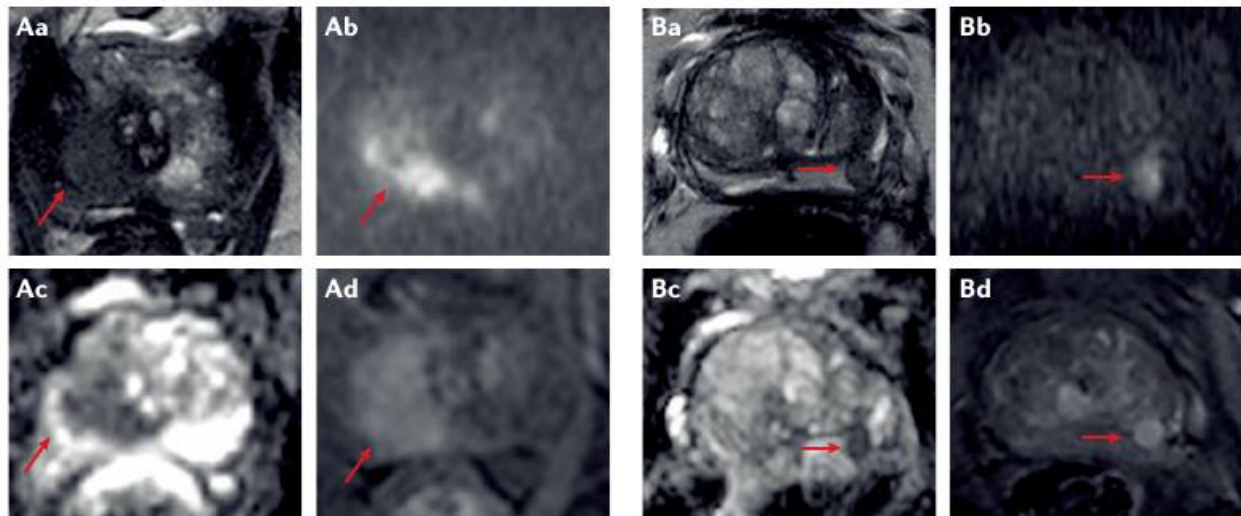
mpMRI cancerous prostate a) There is a tumour in the right peripheral zone. Arrows mark the lesion Aa. T2 lesion is hypointense (dark) Ab. DWI lesion shows restricted movement (bright) Ac. ADC map the lesion is hypointense (dark) Ad. DCEI lesion shows earlier enhancement than the rest of the gland. Lesion A is graded PIRADS 5 targeted biopsy showed a Gleason 4+3.
